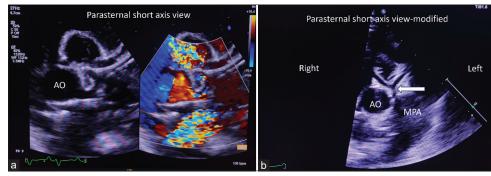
Echocardiogram showing the dilated left coronary artery (a) and origin of right coronary artery (RCA) from main pulmonary artery when retrospectively reviewed (b). Arrow shows anomalous RCA arising from the pulmonary artery. AO: Aorta, MPA: Main pulmonary artery
